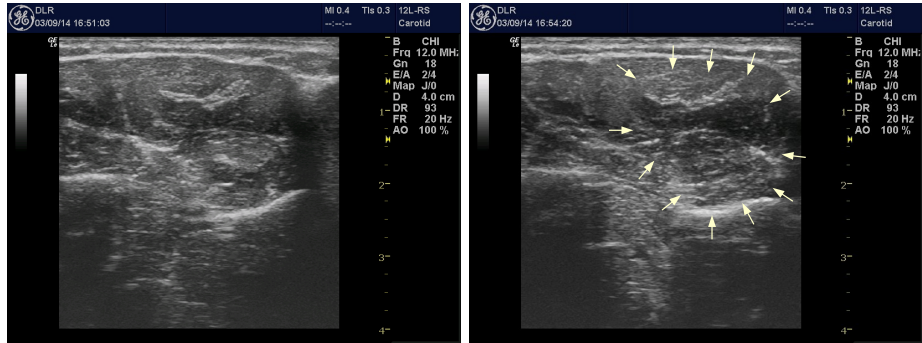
Left ring finger extension recorded with ultrasound, placed as depicted in Fig. 6; left image shows the relaxed state; the right image the activated state.
